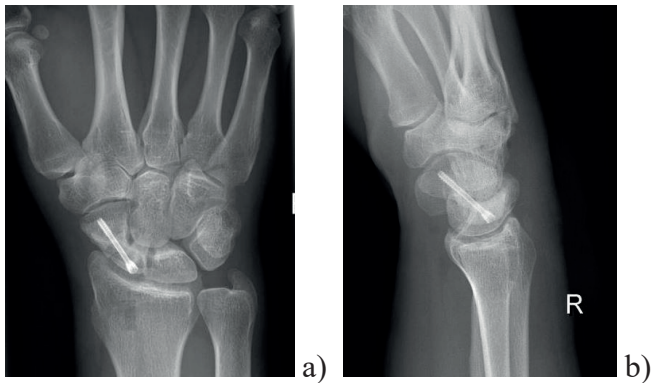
Postoperative X-ray showing fracture fixed with a screw from proximal approach: a) p-a view; b) lateral view
